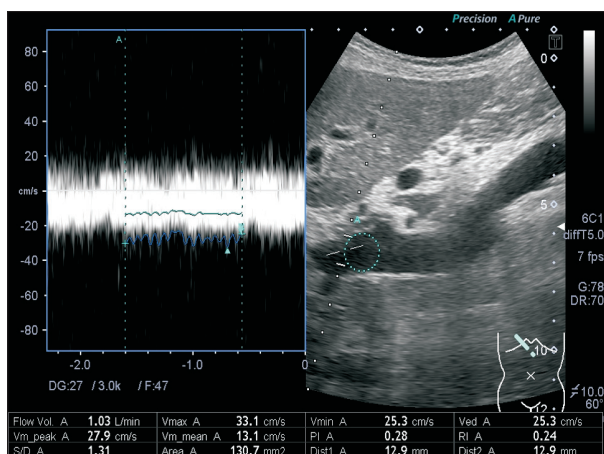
Pulsed Doppler image for portal trunk (68-year-old male, non-B, non-C cirrhosis). The portal trunk was demonstrated as a longitudinal view and sample volume was used with the optimal width to include the vessel. Time-averaged mean flow velocity was obtained from the waveform of the Doppler signal with the beam-vessel angle, which was 60 degrees or smaller. Flow volume was calculated by multiplying mean flow velocity by automatic cross-section of the vessel every 60 seconds.
